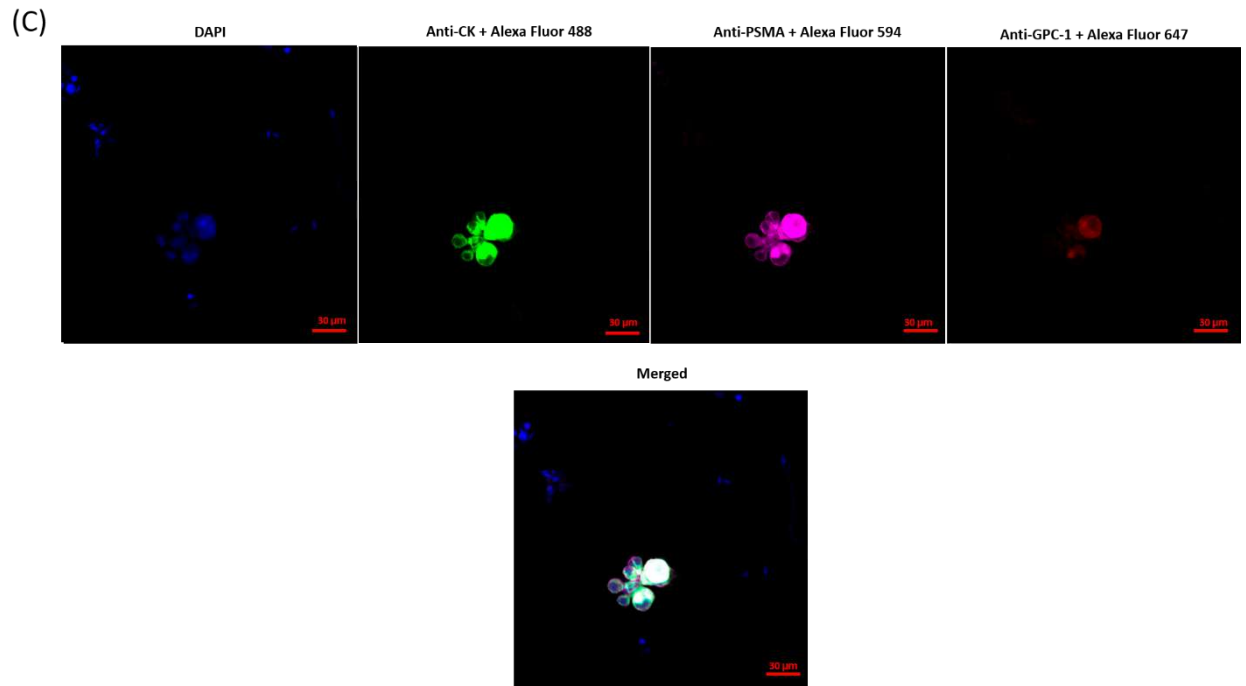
DTCs isolated from diverse biological fluids – blood, urine and semen. In case of blood, the DTCs were the CK+, PSMA+ cells, with the lack of CD45 expression, differently from lymphocytes (CK-, PSMA-, CD45-) which also presented in the blood samples (A). In case of urine, the DTCs were the CK+, PSMA+, GPC-1+ cells, differently from diverse normal epithelial (CK-, PSMA-, GPC-1-) cells which also presented in the urine samples (B). In case of semen, the DTCs were the CK+, PSMA+, GPC-1+ cells, differently from sperm cells (CK-, PSMA-, GPC-1-) and normal epithelial which also presented in the semen samples (C).
